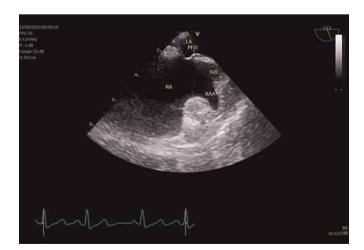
Transoesophageal echocardiogram in patient 2 showing a "tunnel-like" patent foramen ovale (PFO). LA: left atrium; RA: right atrium; RAA: right atrium appendix; SVC: superior vena cava.
